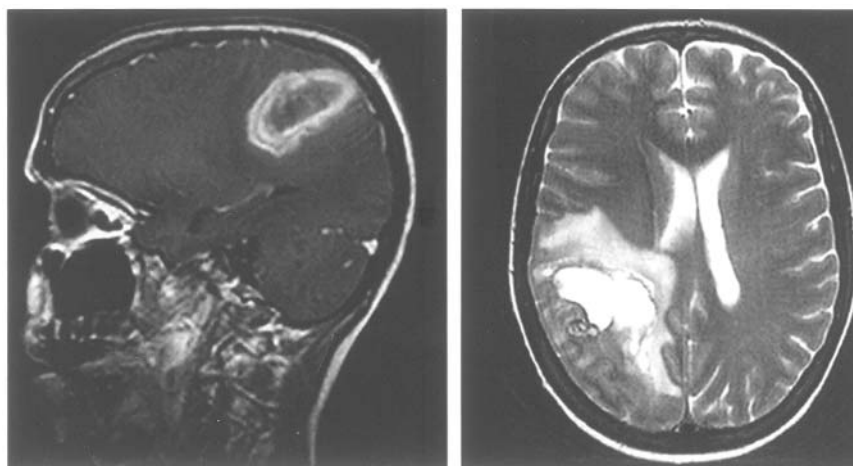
MRI of the brain showing metastatic lesions.
